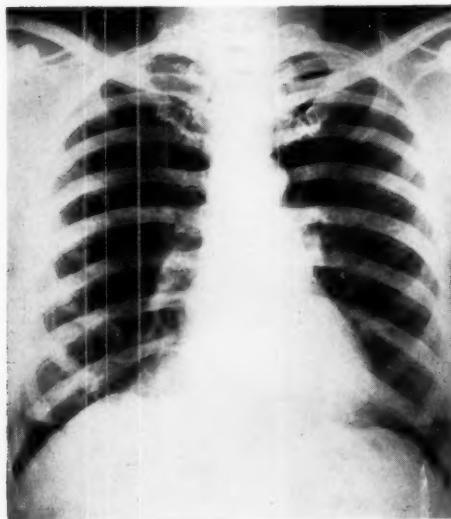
P.A. X-ray of chest showing tumour in right cardio-phrenic angle.
